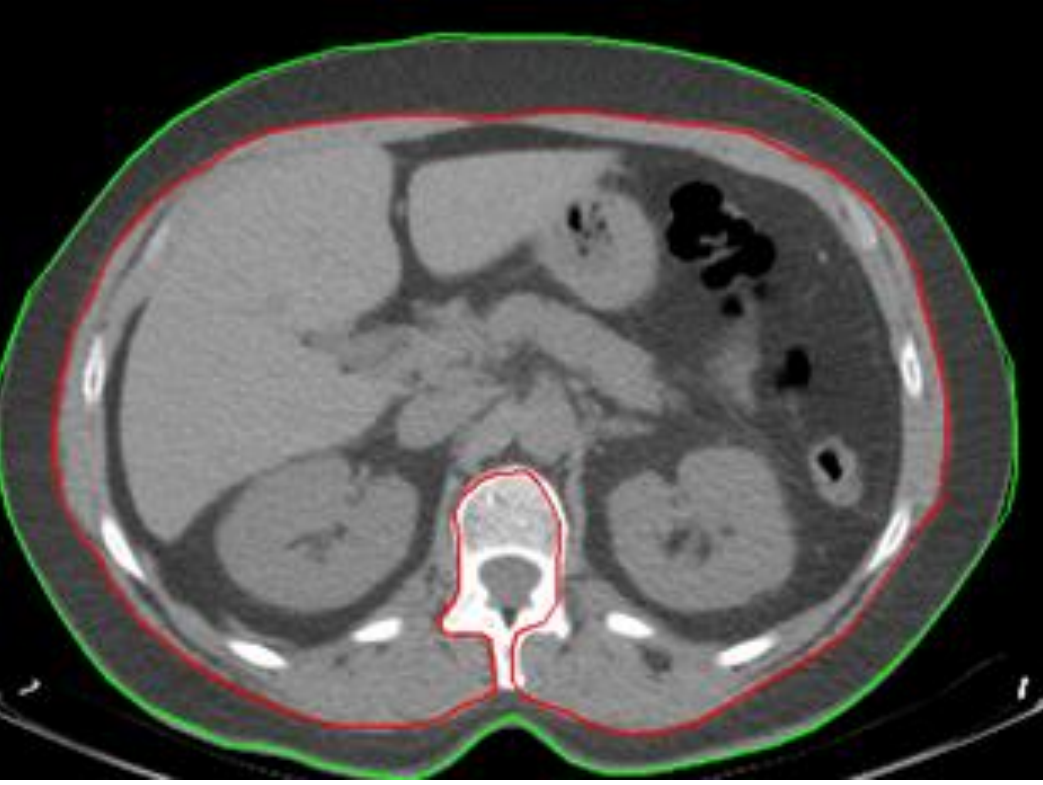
CT-Visceral/Subcutaneous fat
